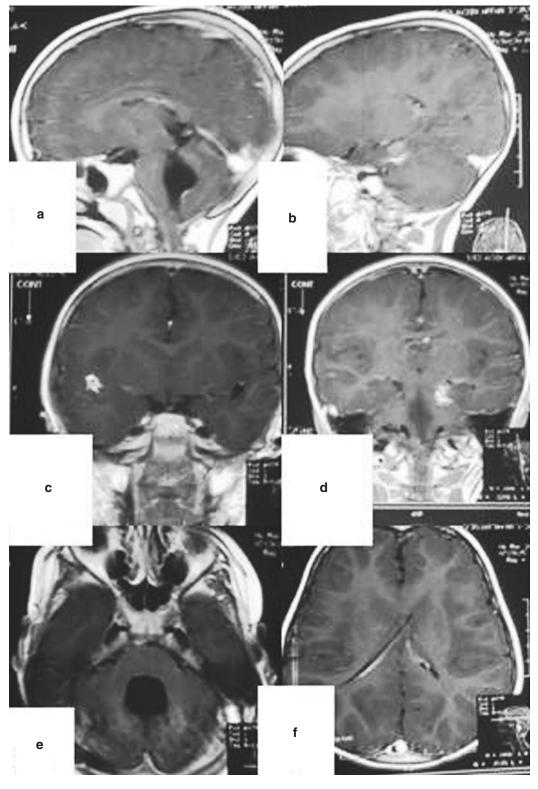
Contrast MRI of the brain at the age of 24 months after VP shunt and ongoing anti-TB therapy; (a, b) sagittal images, (c, d) coronal images, and (e, f)
